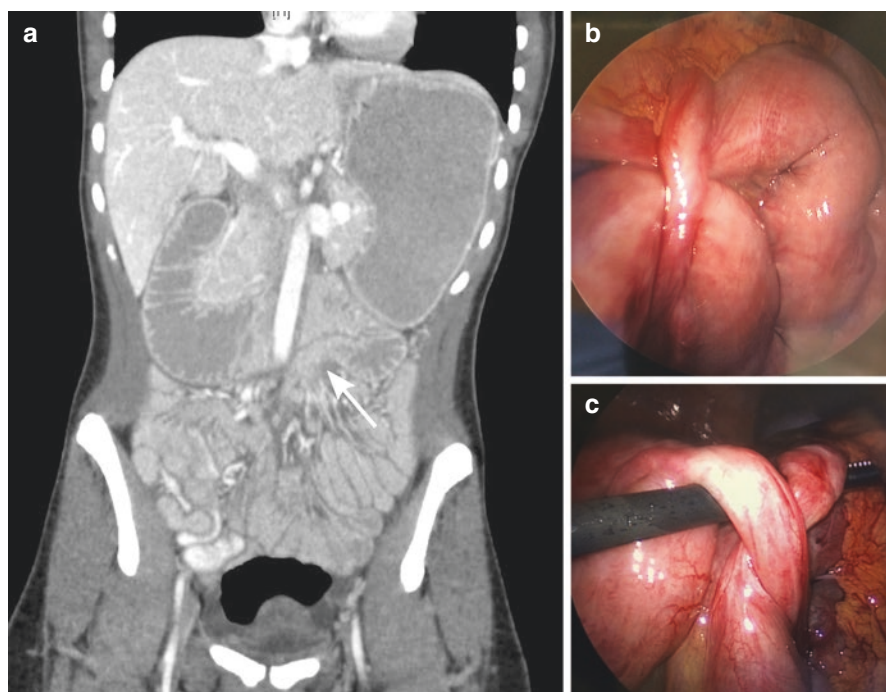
(a–c) Abdominal CT scan images and operative findings in a woman with adhesive small bowel obstruction of the proximal jejunum after laparoscopic total proctocolectomy and ileal pouch-anal anastomosis for familial adenomatous polyposis. Given the proximal point of obstruction and prior laparoscopic approach, the patient was felt to be a good candidate for laparoscopic exploration and lysis of adhesions, which successfully resolved her obstruction. a shows a coronal image with dilated stomach, duodenum, and proximal jejunum. The arrow points to the point of obstruction from the adhesive band. Note the distal decompressed loops of small intestine in the pelvis. b and c show laparoscopic findings, with a broad adhesive band compressing the proximal jejunum
